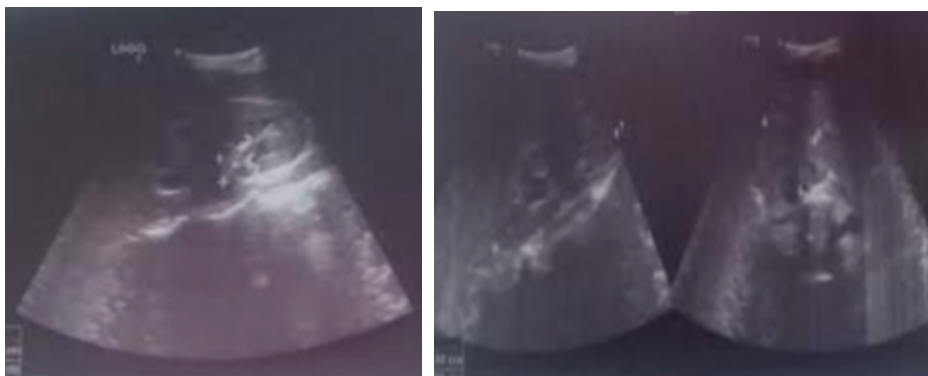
Reno-vesica ultrasound showing finely contented bilateral pyelolo-caliceal dilation echogenic.
